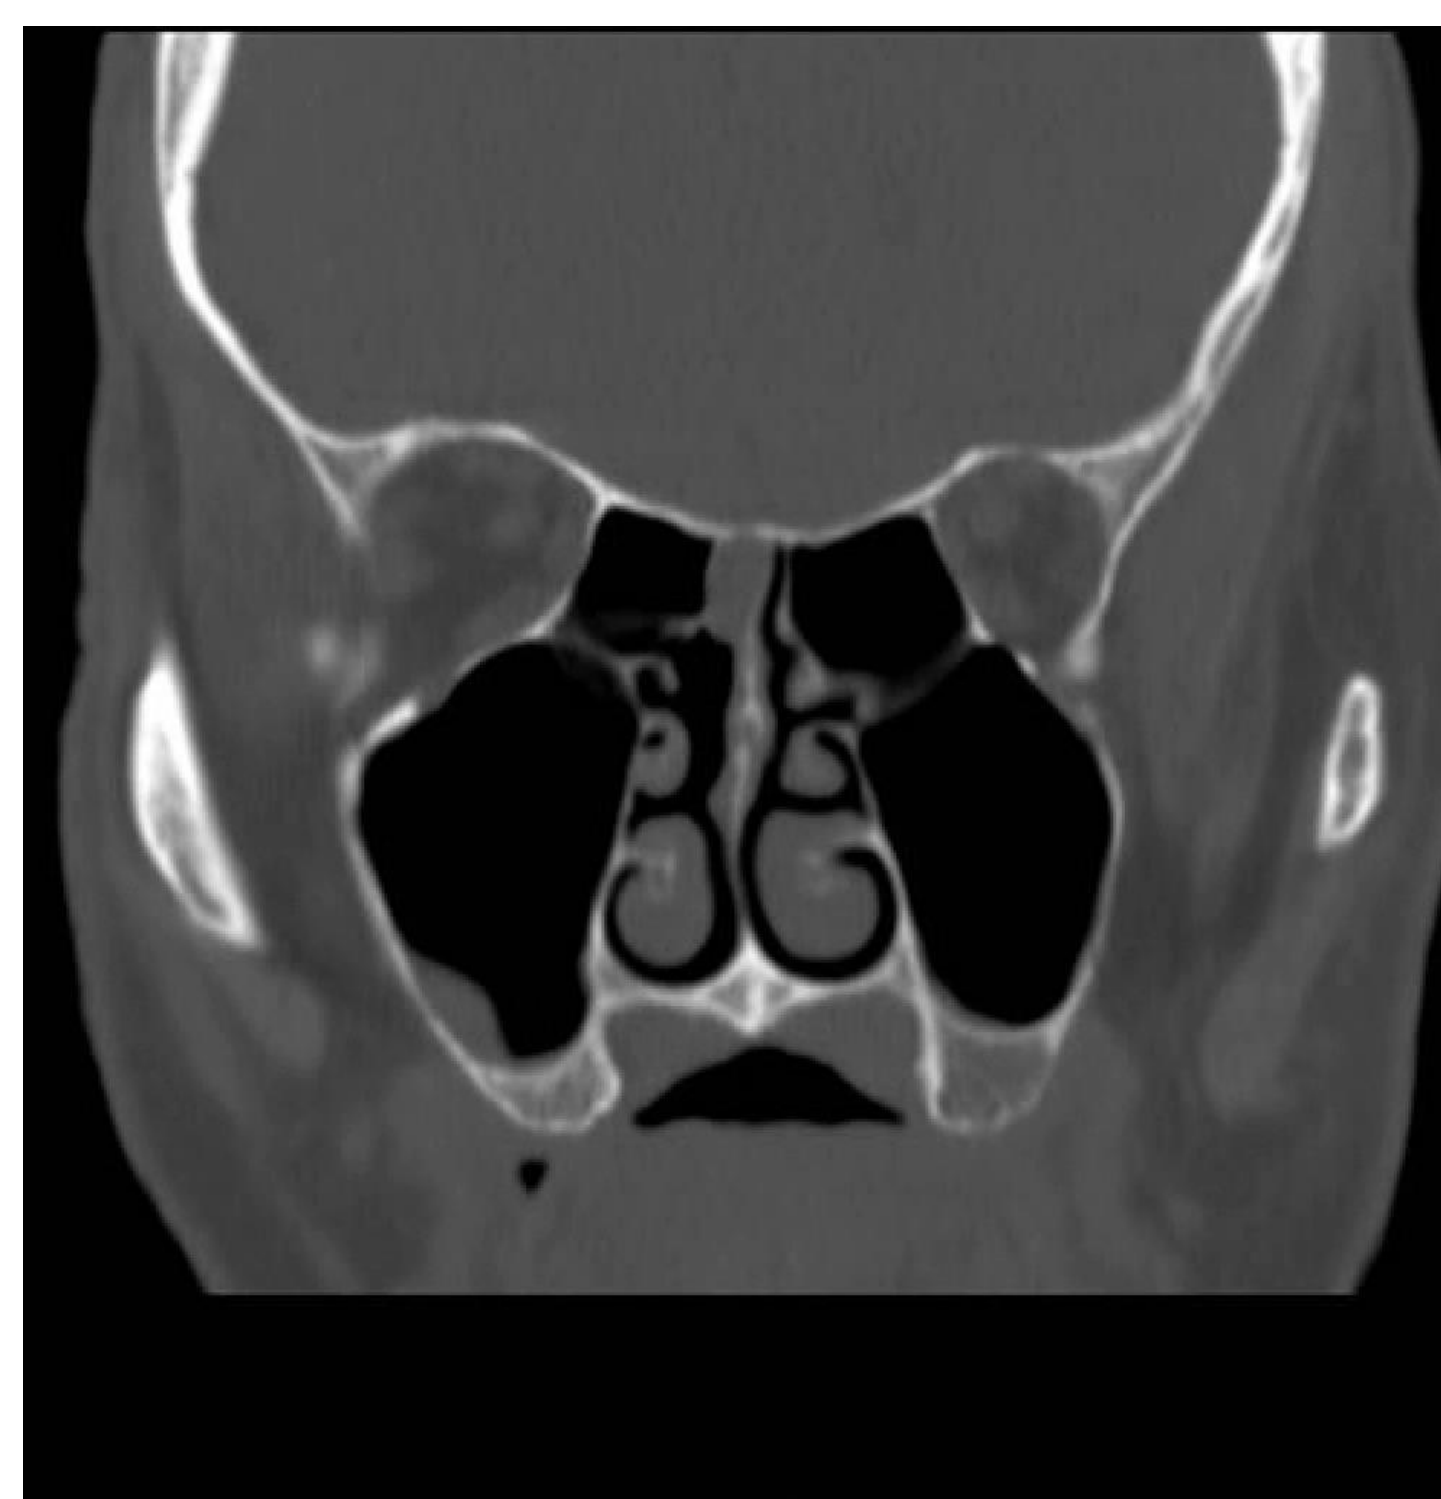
CT post CCRT ; pre surgical excision
